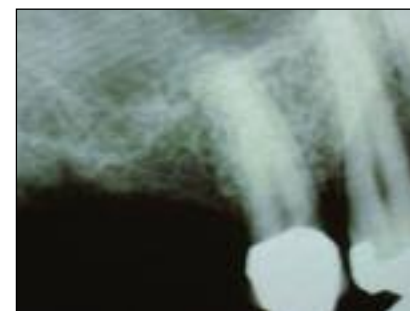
Two further periapical radiographs were taken prior to the selection of the implants
